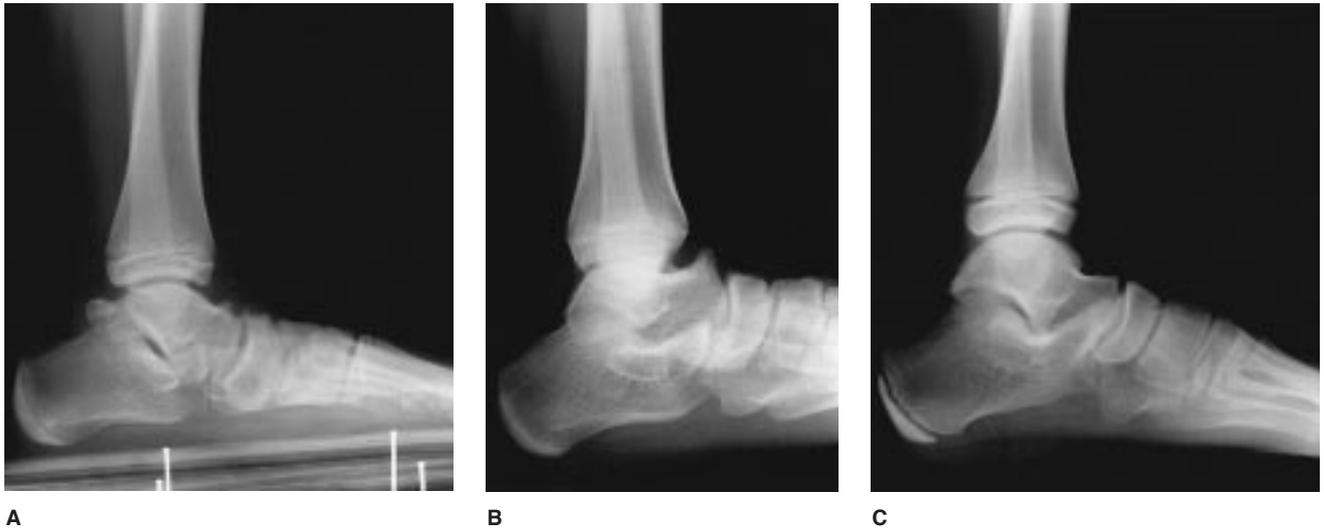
Lateral radiographs of patients with calcaneonavicular coalition. A, Dorsal talonavicular beaking and talar hypoplasia. B, Talar beaking and broadening of the lateral talar process. C, Mild talonavicular beaking.
